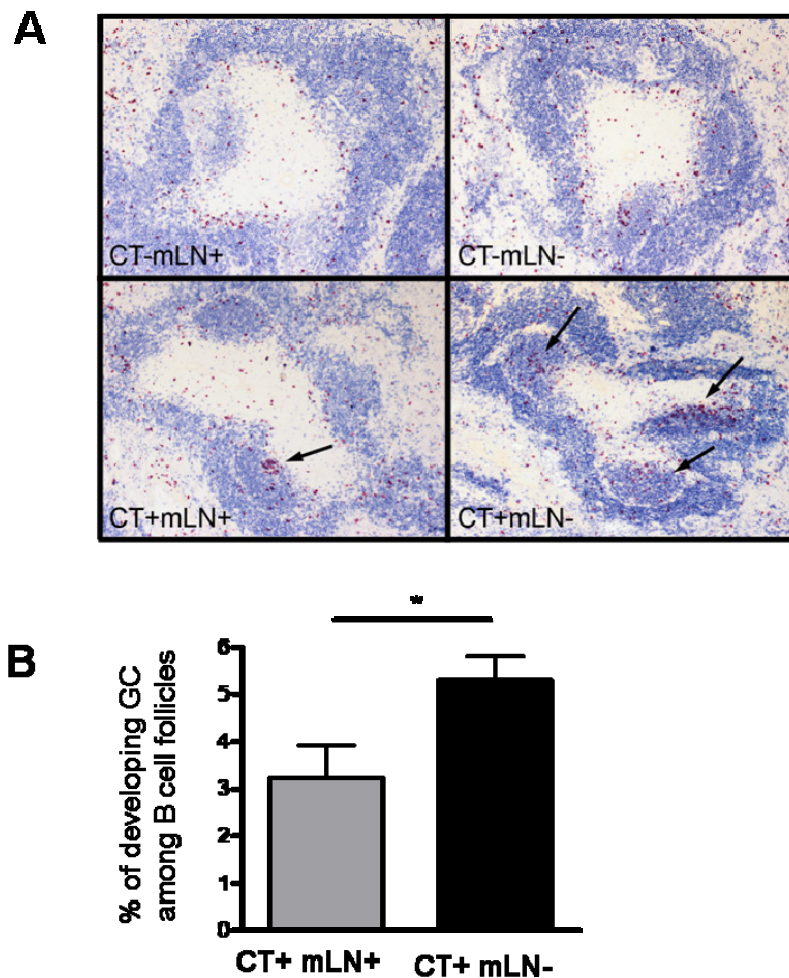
Oral CT treatment leads to an increase of germinal centres
